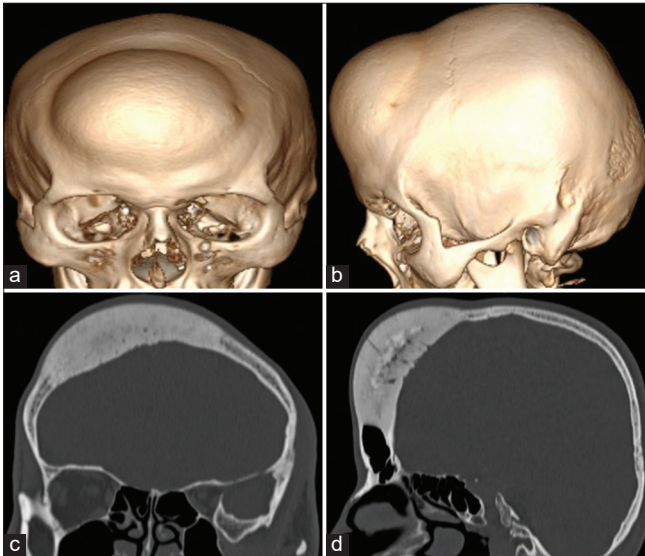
(a and b) Three-dimensional computed tomography (CT) scan reconstruction showing frontal bone hump. (c and d) Bone window of coronal and sagittal CT scan.
